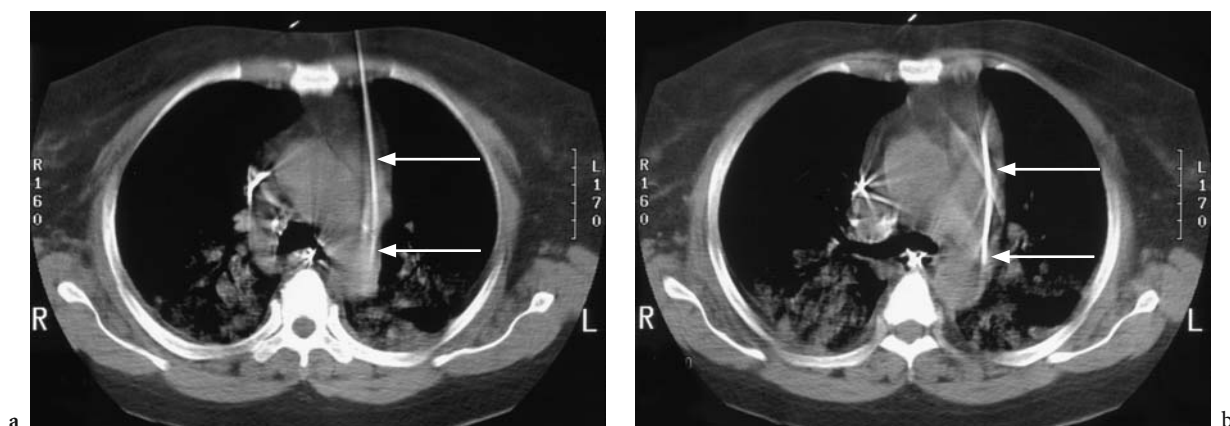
CT-guided percutaneous pigtail catheter drainage of a mediastinal collection in a renal transplant patient (arrows)
